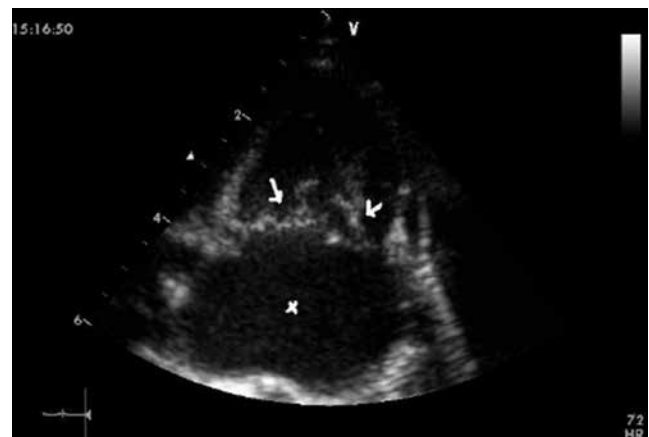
Enlarged left atrium (x) and thickening and curling (white arrows) in the mitral valve are observed on echocardiogram
